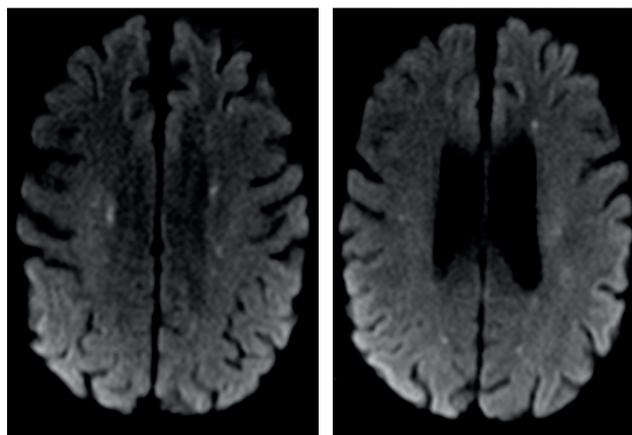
and 1C. Diffusion-weighted MR images at two different levels, showing multiple dot-shaped areas with diffusion restriction in both hemispheres
